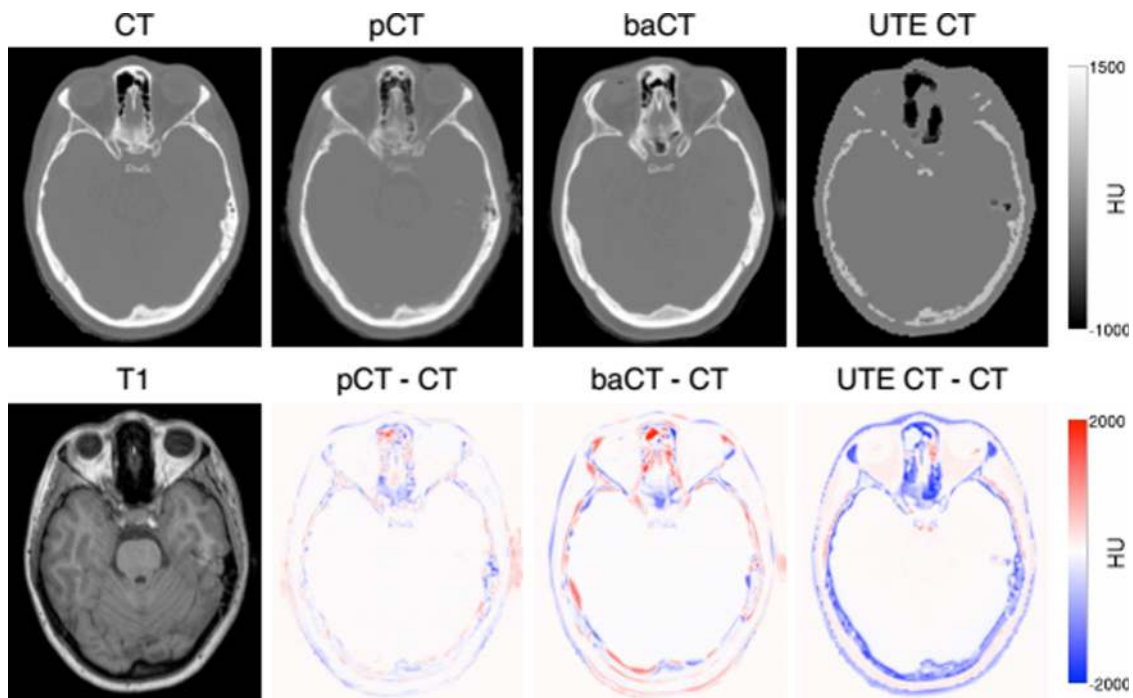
Top row (from left to right): the acquired CT, the pseudo-CT generated by the proposed method, the best atlas CT (baCT), and the UTE CT. Bottom row (from left to right): the acquired T1, the difference between pCT and CT, the difference between baCT and CT, and the difference between UTE CT and CT. Reprinted with permission from Burgos *et al.*, "Attenuation correction synthesis for hybrid PET-MR scanners: Application to brain studies," *IEEE Trans. Med. Imaging* 33(12), 2332–2341 (2014). Copyright 2014 by Creative Commons.
